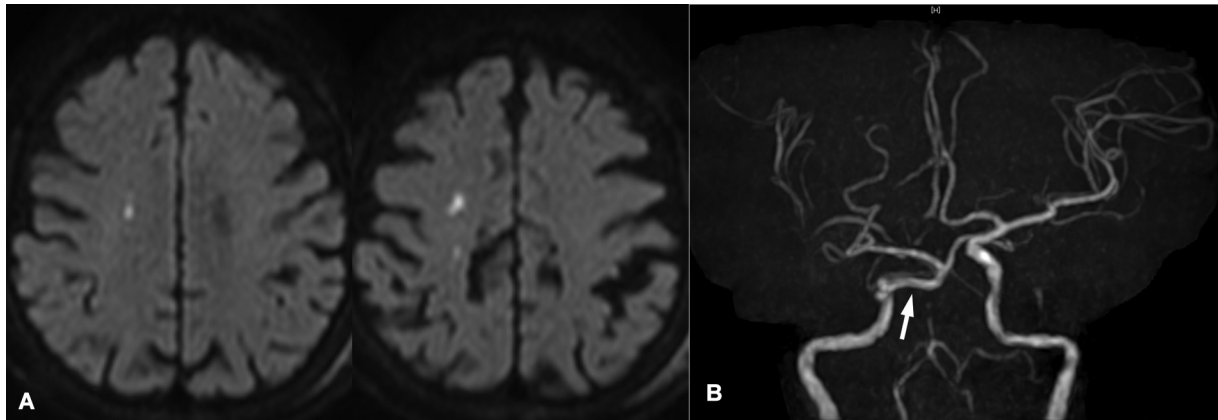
(A) Diffusion-weighted imaging of magnetic resonance imaging showing multiple cerebral infarctions in the right corona radiata. (B) Magnetic resonance angiography showing persistent primitive trigeminal artery (PPTA; arrow) and internal carotid artery occlusion distal to PPTA on the right side.
